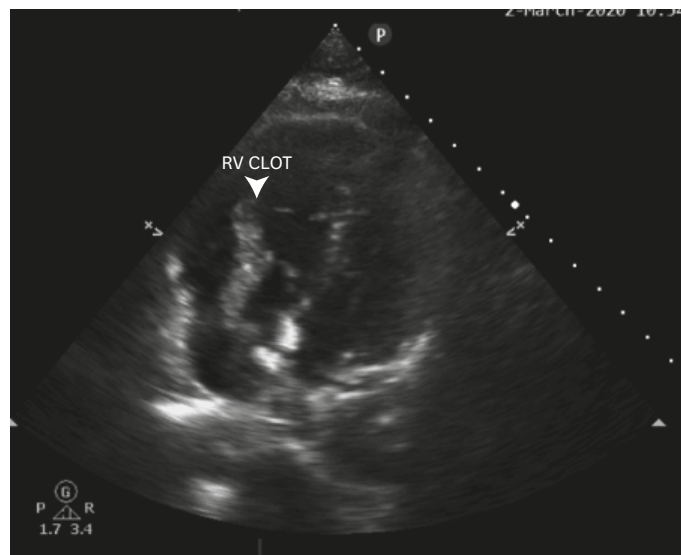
Transthoracic echocardiogram apical 4 chamber view showing a large embolic clot that extended from the right atrium into the RV.
